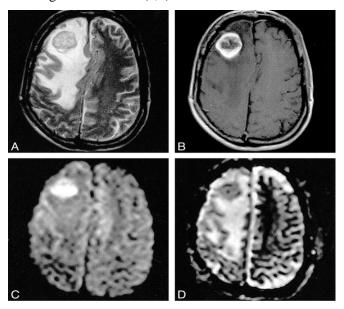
Metastasis The T2-weighted image (A) shows a hypointense mass lesion surrounded by massive edema. On the contrast-enhanced T1-weighted image (B), there is ring enhancement presumably due to central necrosis. With diffusion weighting (C), the central part of the tumor becomes markedly hyperintense, while the ADC map (D) reveals low values, indicating restricted diffusion.
